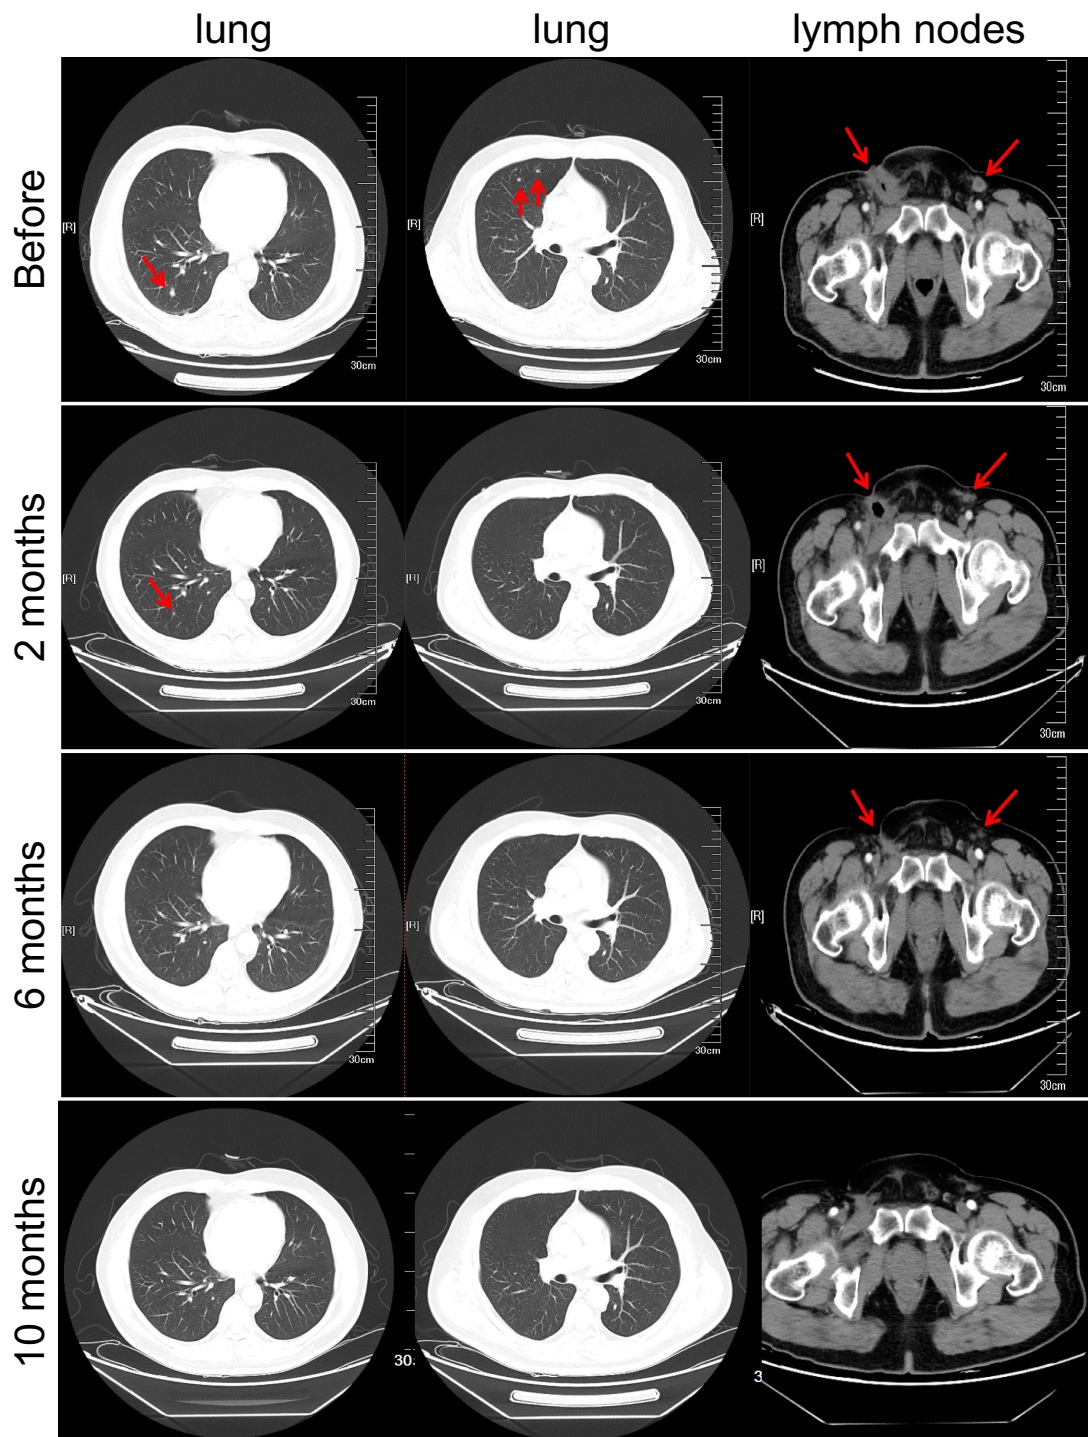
CT. result of tumor lesions in lung and lymph nodes before, or after 2 months, 6 months and 10 months of immunotherapy as indicated by arrows. Lesions continued recessing.
